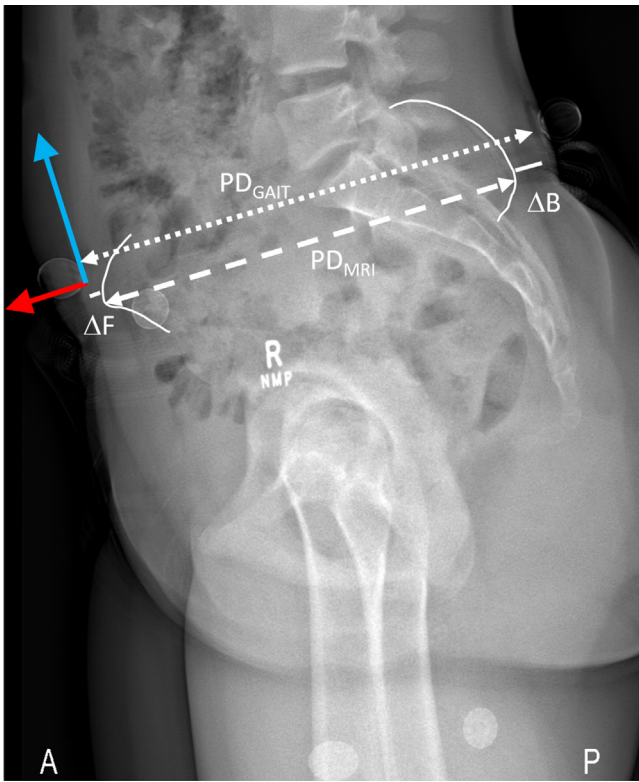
Sagittal plane image from EOS [4] centred on the pelvis of one subject equipped with external markers for gait analysis. The red and blue arrows represent the anterior–posterior and superior–inferior axes of the pelvis as defined from external markers. The pelvic depth measured from the external markers position (PD_{GAIT}) and from the bony landmarks (PD_{MRI} , as it would have been measured from MRI images) are presented as well as ΔF and ΔB , the thickness of soft tissue in front and behind the bony landmarks.
